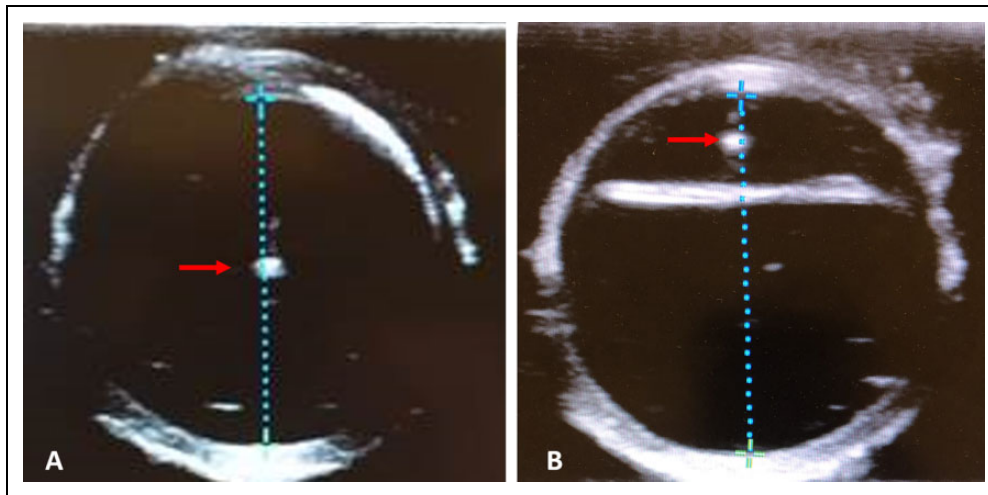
Ultrasound image of diameter and pressure measurement in the true (A) and false (B) lumen. Arrow: the tip of the arterial catheter. Line: anterior–posterior (AP) lumen diameter.
